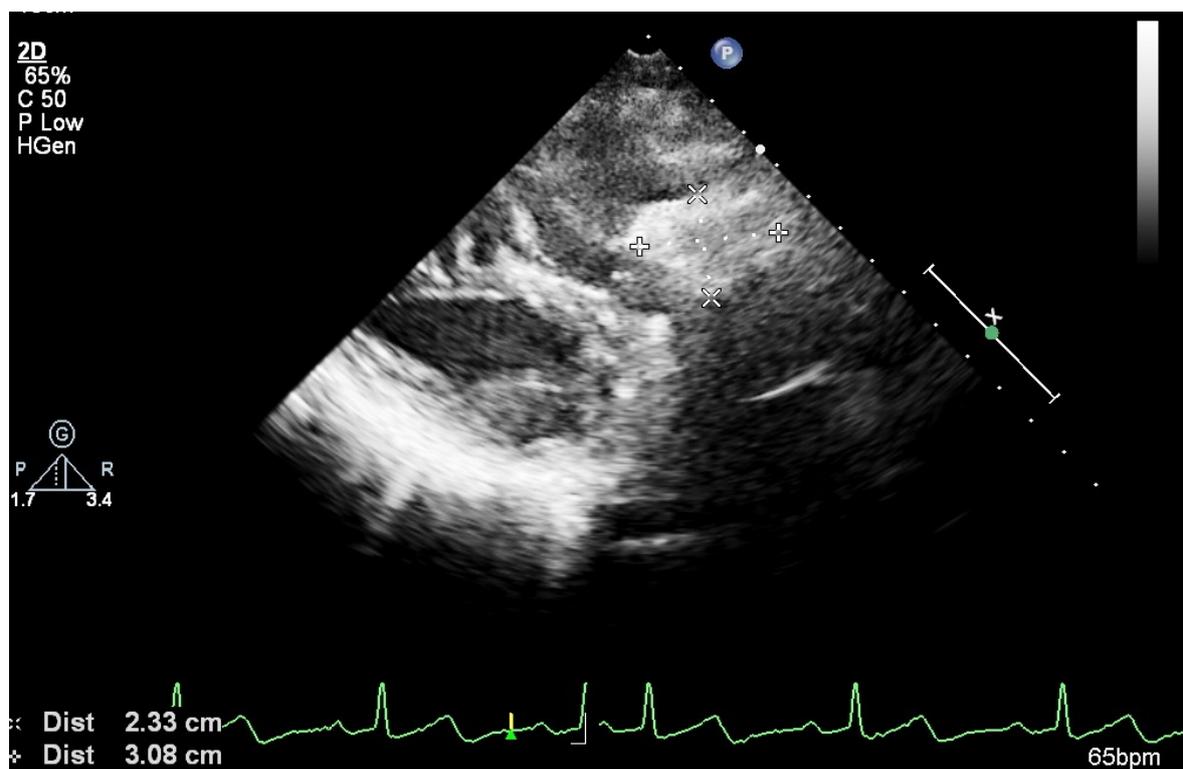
2D Echocardiogram modified parasternal long axis view, showing mass attached to pulmonary valve causing right ventricular outflow obstruction
